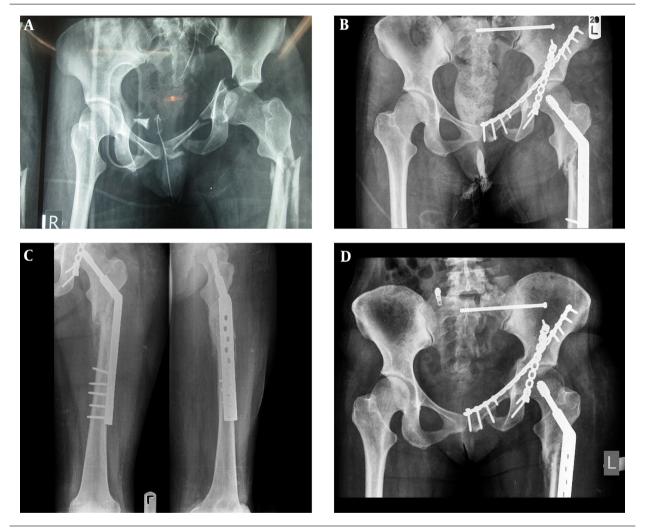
A, Preoperative Radiography; B, Early Post Operative Radiography; C and D, 6 Months Follow up
